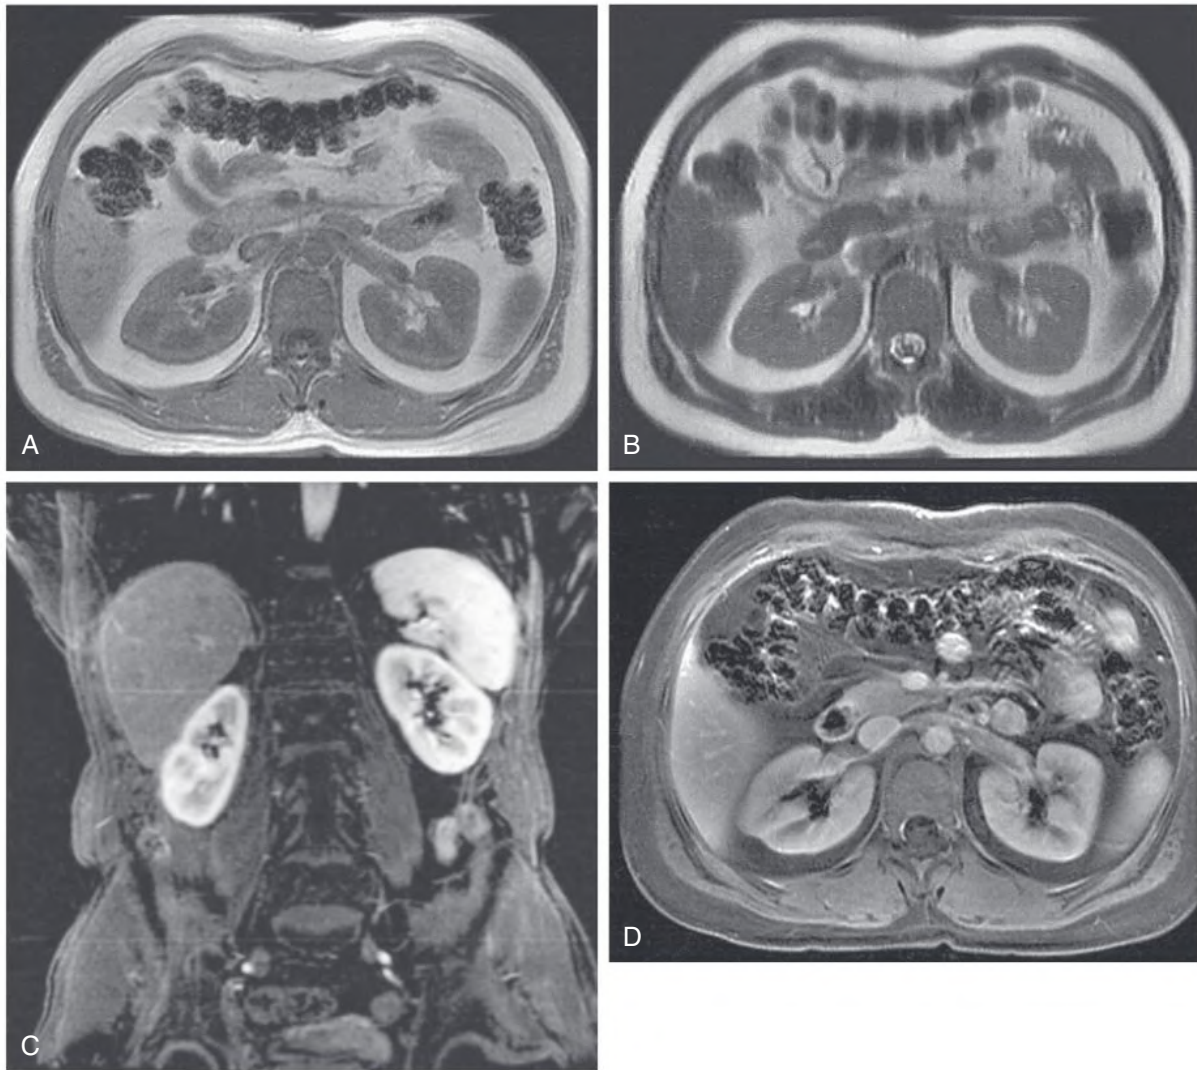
Normal Magnetic Resonance (MR) Images Through Kidneys. (A) T1-weighted MR image. Note the distinct corticomedullary differentiation. (B) Fast spin echo MR image. Urine in the collecting tubules causes the high signal within the renal pelvis on this sequence. (C) Coronal T1-weighted, fat-suppressed MR image after contrast administration. (D) Axial T1-weighted, fat-suppressed image after contrast administration.
